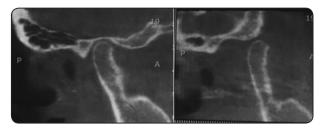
Shows: CBCT confirming diagnosis and excluding presence of cysts within articular eminence
